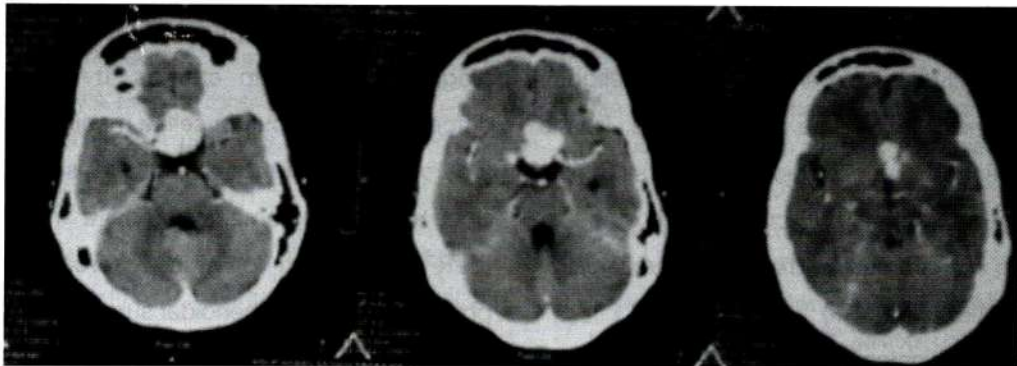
A CT Scan of a 44 year old lady diagnosed with tuberculum selae meningioma. Note the homogenous enhancement and lobulated configuration but no hiperostosis of the bone is present.
